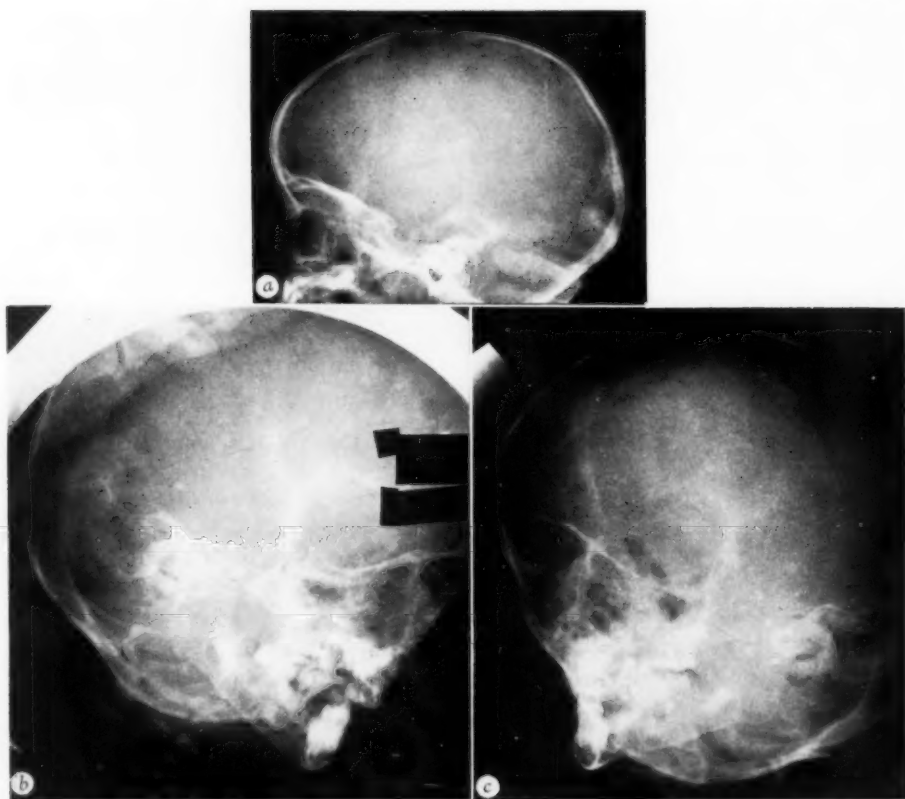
(a) Lateral roentgenogram of skull to demonstrate normal "infantile type" of sphenoid. (b) and (c) Roentgenograms of skull taken with patient in Rhese position, showing that left optic foramen (b) is approximately four times the caliber of the right (c).
